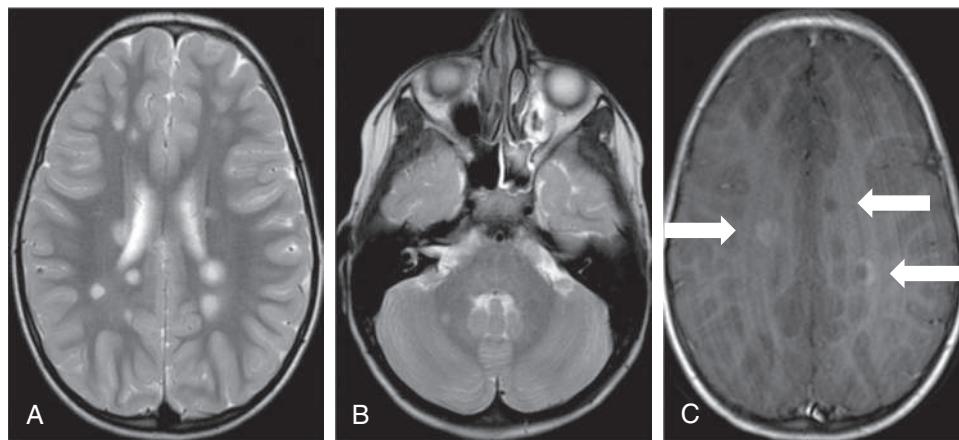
5-year-old patient diagnosed on imaging with MS after presentation with left-sided weakness. A, Axial T2-weighted MRI of brain shows multiple discrete, ovoid white matter lesions in the periventricular region and cortical, juxtacortical, and infratentorial lesions (B). C, Axial T1-weighted area of hypointensity and two contrast-enhancing lesions (arrows).
